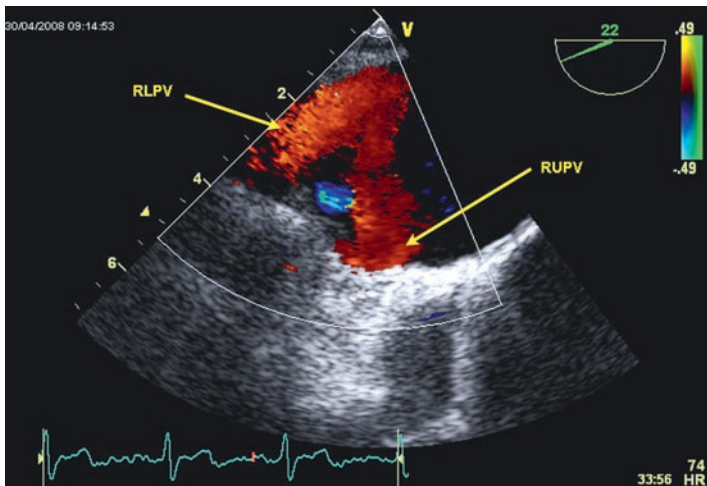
Color Doppler demonstrating two distinct right pulmonary vein inflows (red). The more horizontal flow is from the lower (RLPV) and the more vertical flow is from the upper (RUPV) pulmonary vein.
